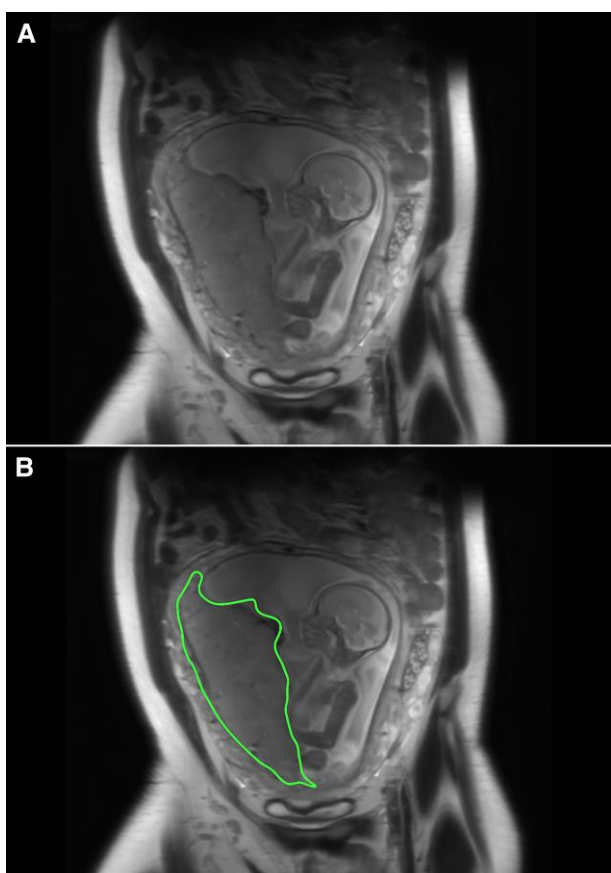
Placental volume. To determine placental volume, placental regions of interest were traced manually. The two images above are the same; the top image (A) shows an MRI slice in the coronal plane of the placenta and fetus; the bottom image (B) shows the placental region traced in green. This was repeated for all MRI slices in which the placenta was visible, for each the axial, coronal, and sagittal planes, allowing for the determination of placental volume.
